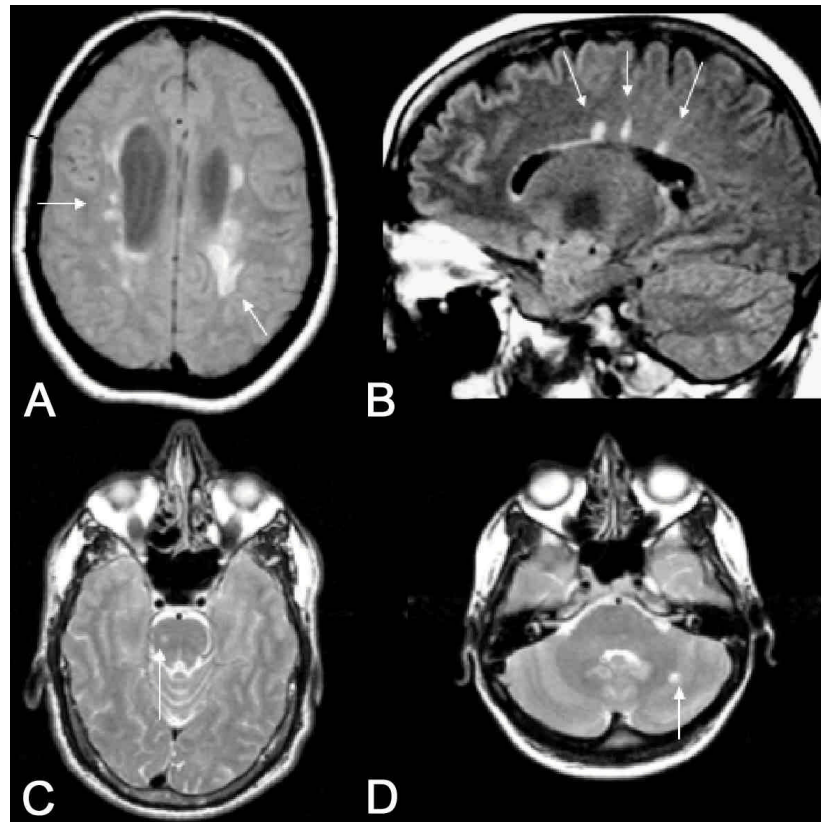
a: Axial T2-PD weighted image in a 44 year-old woman with SP MS showing multiple hyperintense lesions in the periventricular white matter (arrows). The lesion are characteristic for MS including a size of generally >5mm, oval/ovoid morphology and that many directly contact the ventricular ependyma; b: Sagittal FLAIR image in a 44 year-old man with RR MS showing multiple pericallosal lesions (arrows) with a classic perivenular orientation (Dawson's fingers); c/d: Axial T2-WI of a 33 year-old man with RR MS demonstrating typical hyperintense lesions in the pons (c, arrow) and left cerebellum (d, arrow).
